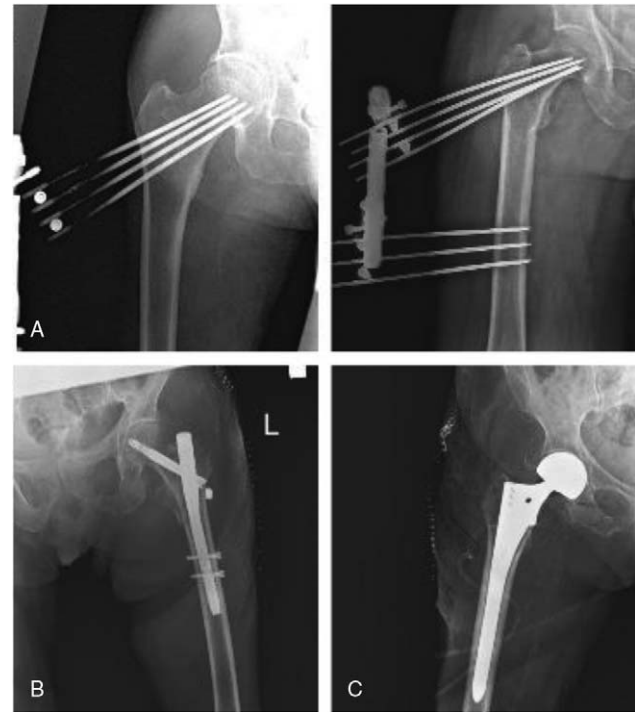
Postoperative X-ray images; (A): External Fixation, (B): PFN, (C): Hemiarthroplasty.
